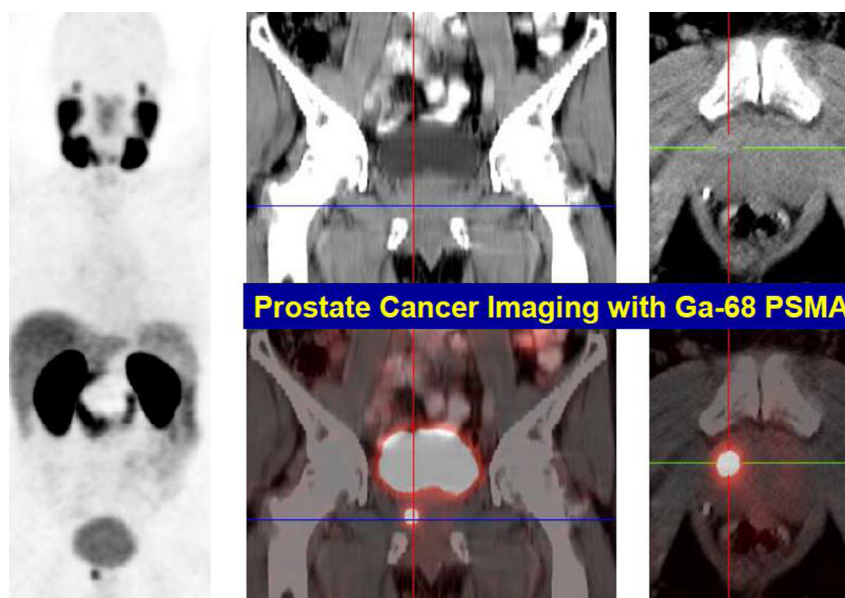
PSA = 8 ng/mL; initial transrectal ultrasound-guided prostate biopsy = negative. ^{68}Ga PSMA PET/CT shows tumor in the right prostate lobe. Repeat targeted prostate biopsy = Gleason 4 + 5 = 9. CT, computed tomography; Ga, gallium; PET, positron emission tomography; PSMA, prostate-specific membrane antigen. (Color version available online.)
